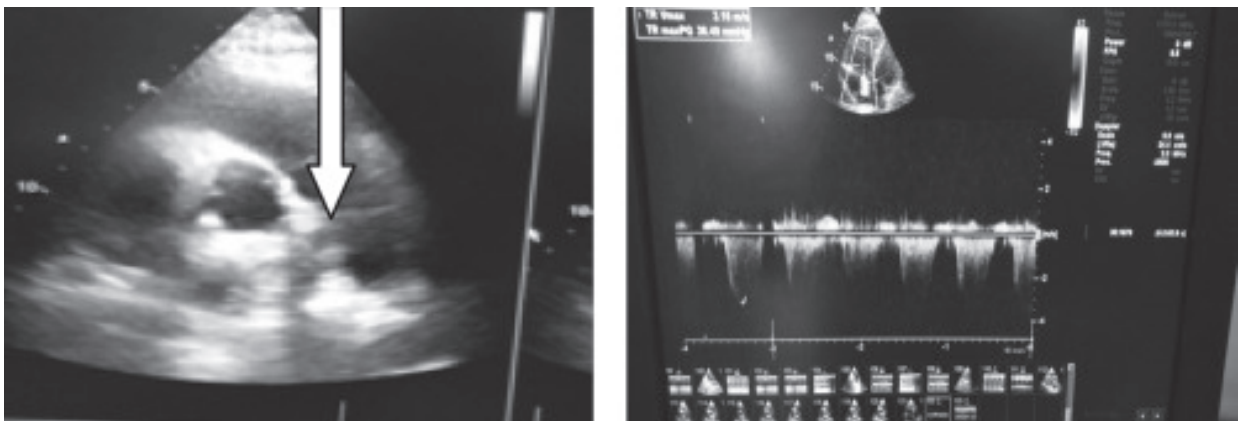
Echocardiography showed thrombus at right pulmonary artery and tricuspid regurgitation
